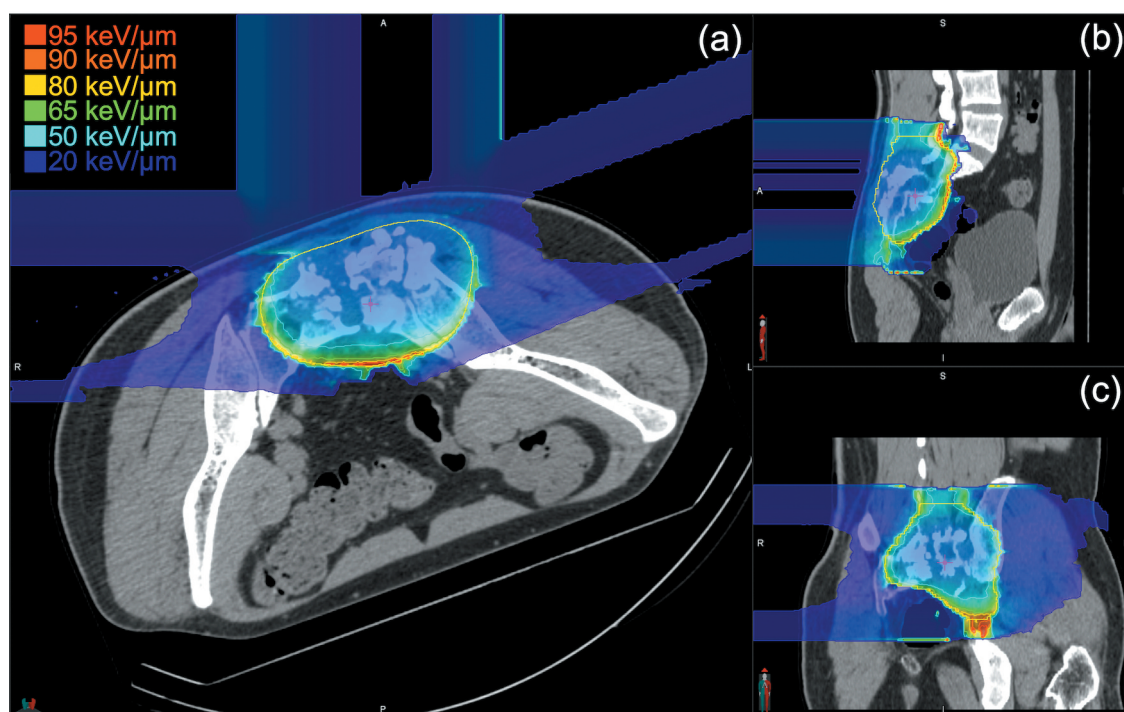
Dose-averaged linear energy transfer (LET_d) distributions in the planning tumour volume (PTV). The combined LET_d distribution was calculated outside the treatment planning system and then registered with the CT image. (a) Axial view, (b) sagittal view, and (c) coronal view. The image was prepared by fusing the treatment planning image with the image showing the LET_d distribution in a rainbow-colored pattern. The yellow circle shows the PTV edge. The pink cross denotes the iso-centre.
